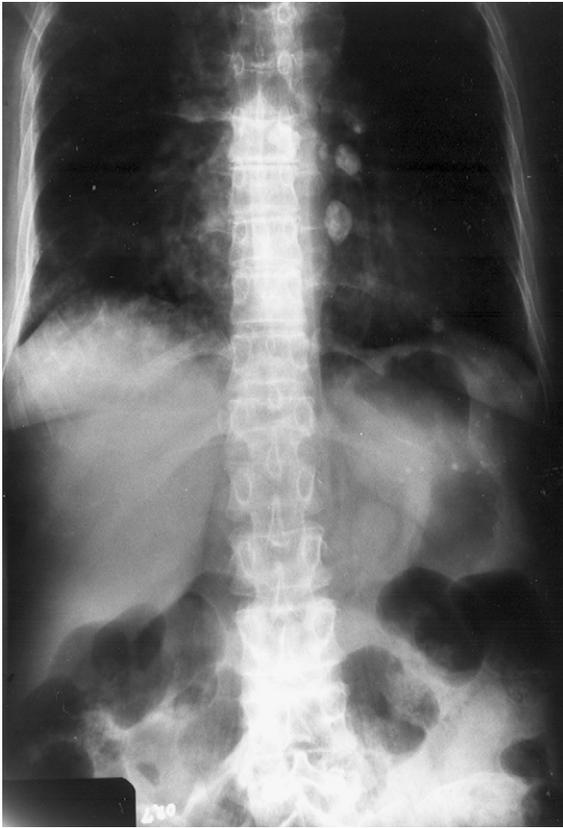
Calcified histoplasmosis Rhanke complex. AP chest radiograph demonstrates a subtle calcified nodule in the left lower lobe just above the dome of the diaphragm and several large calcified left hilar and subcarinal lymph nodes. Tiny calcifications within the left upper quadrant of the abdomen represent splenic granuloma from healed systemic dissemination.
